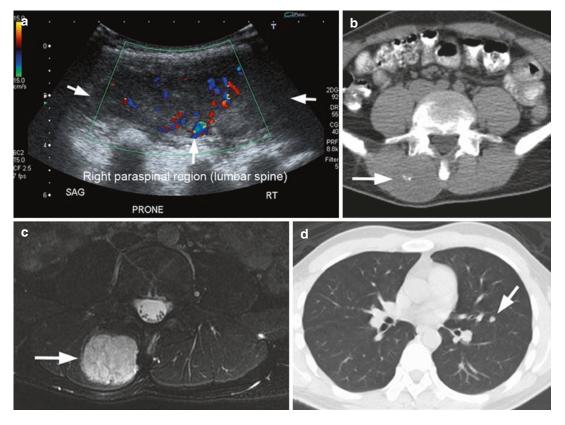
(a-d) Solitary fibrous tumor. Intramuscular cellular tumor in the right paraspinal muscles in a 31-yearold man developing pulmonary metastasis. (a) Ultrasound image depicts a heterogeneous, hypoechoic mass (arrows) with prominent internal vascularity. (b) Non-contrast axial CT reveals a mass iso- to mildly hypodense to the muscle and a small internal calcification. (c) Axial T2-weighted MR image shows a predominantly hyperintense mass (*arrow*) with heterogeneous regions of low
